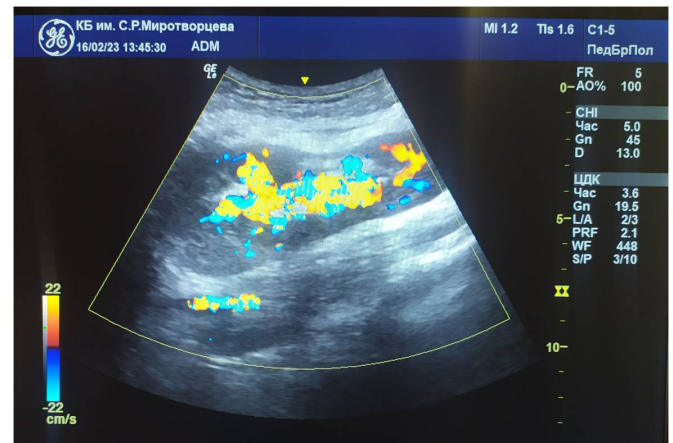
Ultrasonogram of a kidney graft in color Doppler mode
